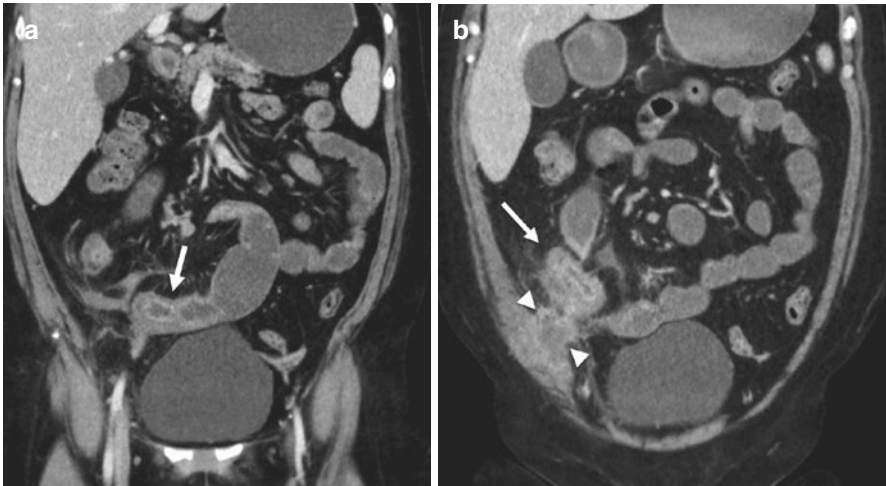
Coronal CT enterography image (a) showing wall thickening with increased mural and mucosal enhancement in the terminal ileum (arrows in a and b) and upstream small bowel dilatation consistent with a stricture with active inflammation. There is an associated adjacent abscess (arrowheads in b). There were also fistulas to the adjacent small bowel and appendix (not shown)
